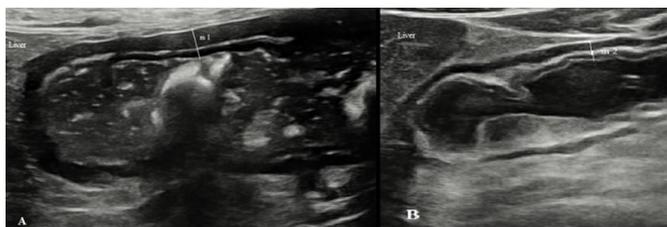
The gastric antrum of a patient with epigastric pain who was diagnosed with *H. pylori* after endoscopic biopsy is shown by transabdominal ultrasonography before (Picture A) and after treatment (Picture B). The patient had increased antral wall thickness ($m_1=7.6$ mm) which regressed after appropriate treatment ($m_2=4.3$ mm).
